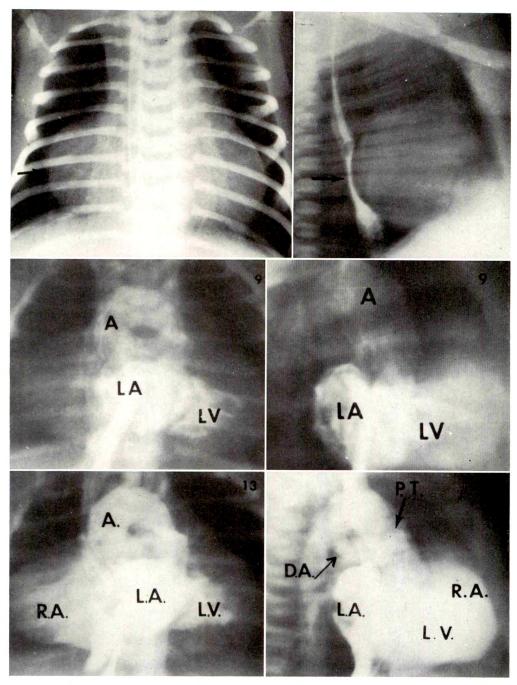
Upper left and right: Conventional roentgenograms demonstrate aneurysmal dilatation of the right atrium on the frontal projection. The lateral projection shows the typical left atrial enlargement (arrow). Center left and right: Early angiocardiograms show streaming through the right atrium with dense filling of the left atrium and early filling of the left ventricle and aorta. Lower left and right: Later angiocardiograms show diffuse opacification of the enlarged right atrium. The pulmonary trunk (PT) has filled via the ductus arteriosus (DA).
